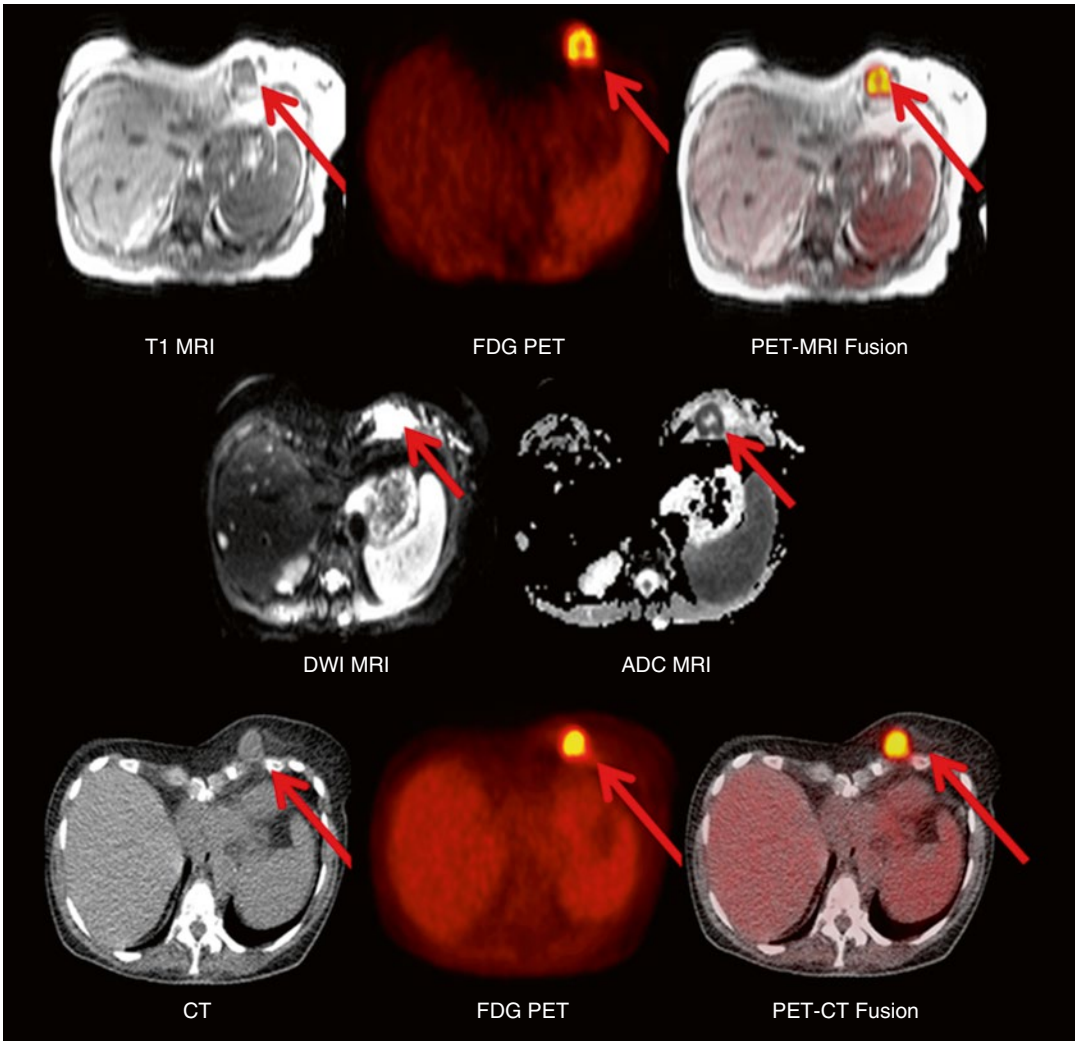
PET-MR clinical example. *Top row* shows T1 MR and FDG PET of thorax acquired simultaneously using a hybrid PET-MR device. *Middle row* shows
